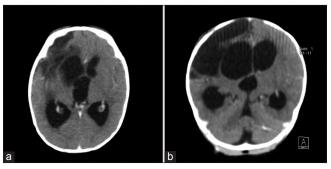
(a) Axial view and (b) Coronal view of a CT scan showing dilation of the ventricular system with signs of communicating hydrocephalus.
